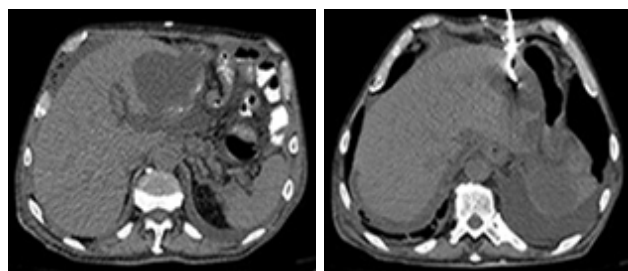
Postoperative peripancreatic collection and percutaneous CT drainage
